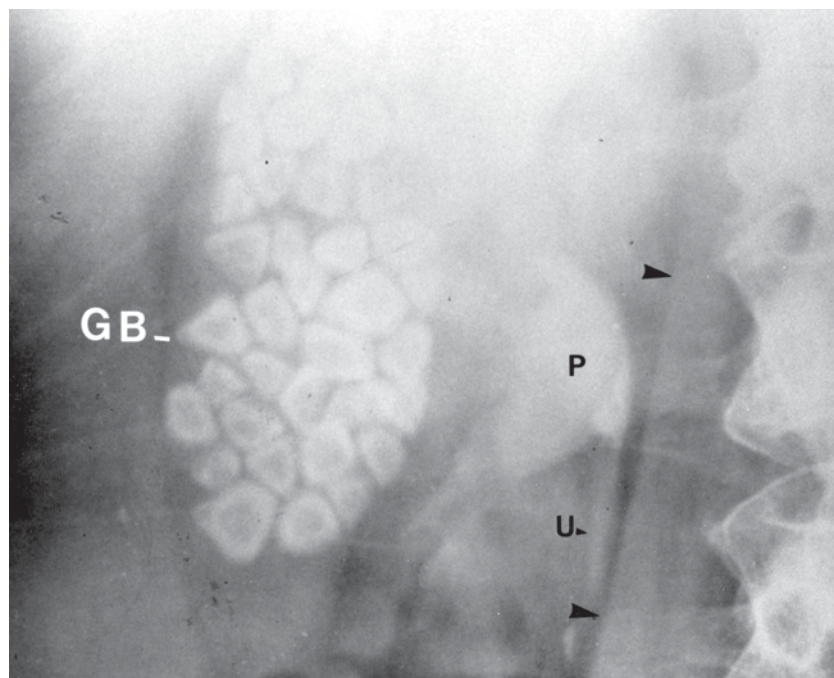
X-Ray of the Gallbladder Showing the Presence of Numerous Gallstones
